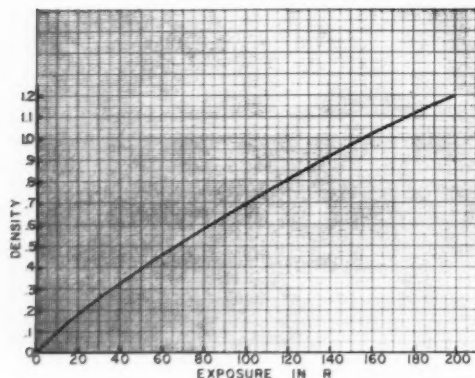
Calibration curve of density vs. exposure in roentgens.
